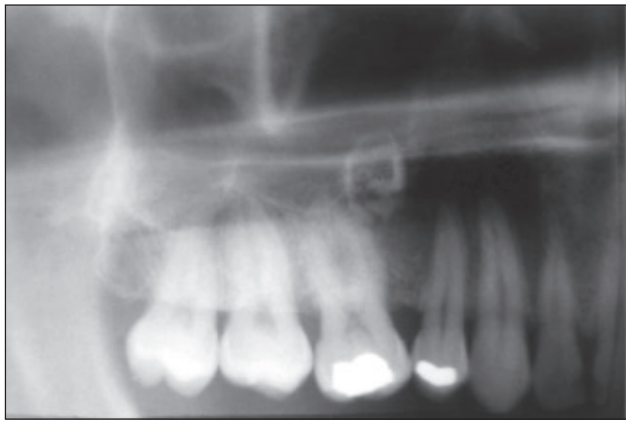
Periapical radiograph of a 30-year-old male with an impacted maxillary right second premolar showing evidence of resorption.
